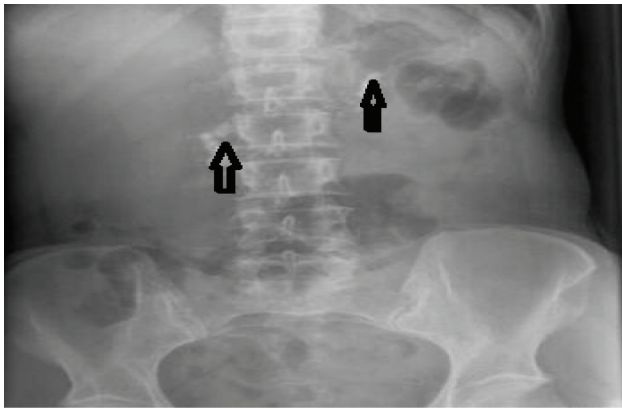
X-ray abdomen showing presence of pancreatic calculi at the level of lumbar 1 (left Side)& 2 (right side) vertebrae
